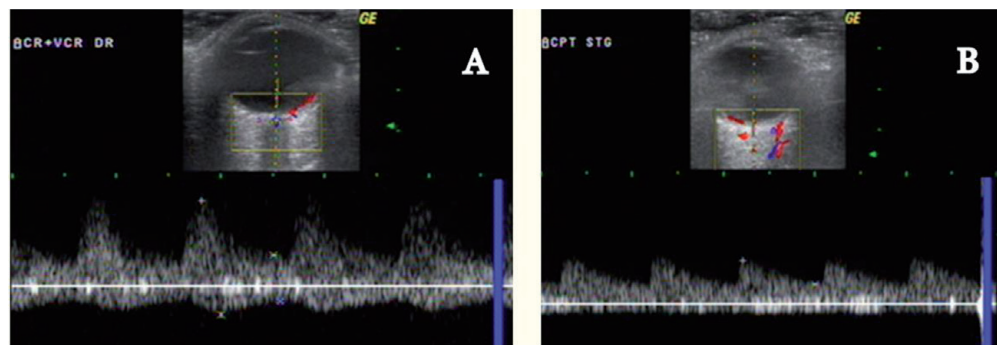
Color Doppler imaging (CDI) of orbital (retro-bulbar) vessels: (A). central retinal artery (CRA); (B). posterior ciliary arteries (PCAs) [15].
